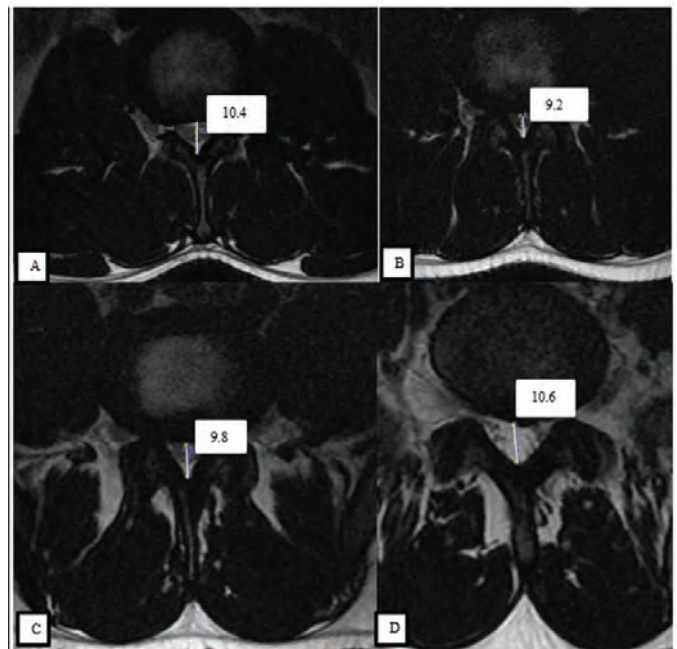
Axial T2w MR images of a 20-year-old male with short pedicles showing the long segment of narrowing of the central spinal canal at all four levels; L2-L3 (A), L3-L4 (B), L4-L5 (C) and L5-S1 (D). The associated compressed appearance of the central spinal canal is noted
